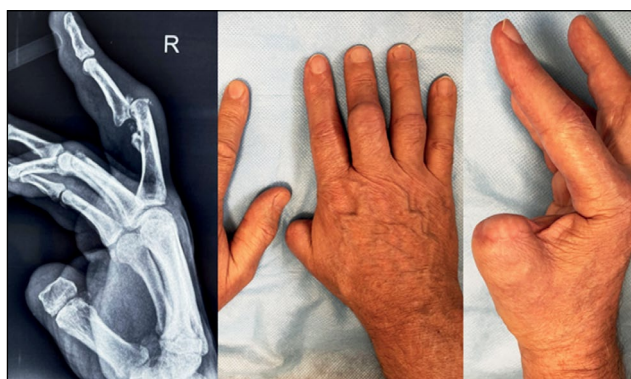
Appearance and X-ray picture.
